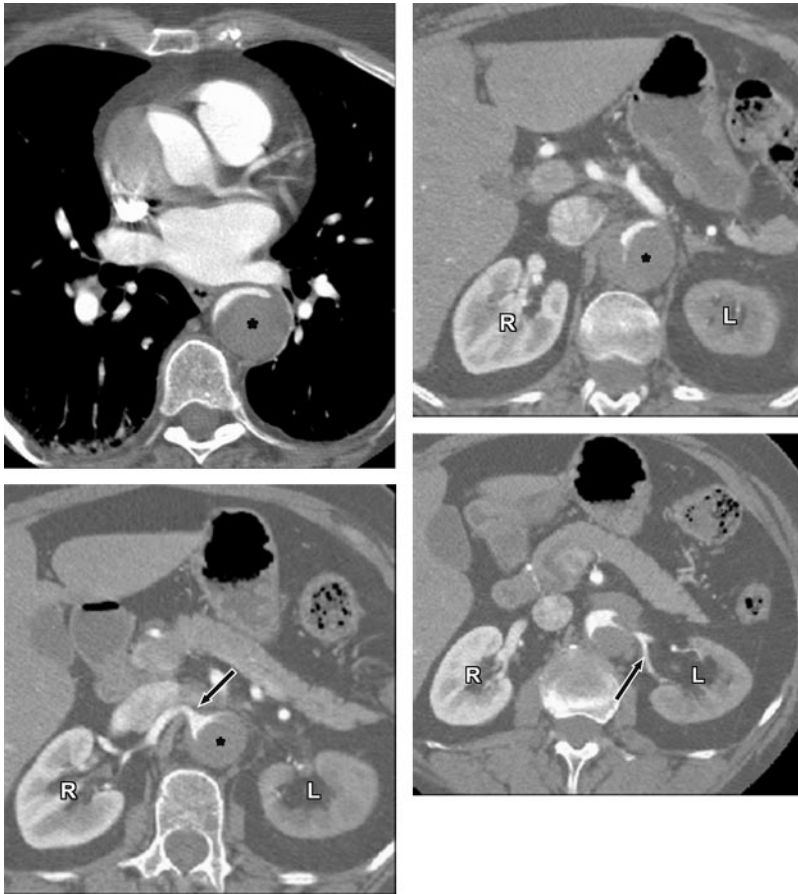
Type A Aortic dissection with thrombosed false lumen and left renal artery involvement depicted on axial CT images. Demonstrates marked narrowing of the true lumen, patent right renal artery arising from the true lumen (bottom left, arrow), and narrow left renal artery compressed by thrombus in the false lumen, with secondary decreased enhancement of the left kidney compared with the right kidney. Top left, At the level of the left main coronary artery. Top right, At the celiac axis. Bottom left, At the right renal artery (arrow). Bottom right, At the left renal artery (arrow). *Thrombus in false lumen. CT indicates computed tomographic imaging; L, left kidney; and R, right kidney.
